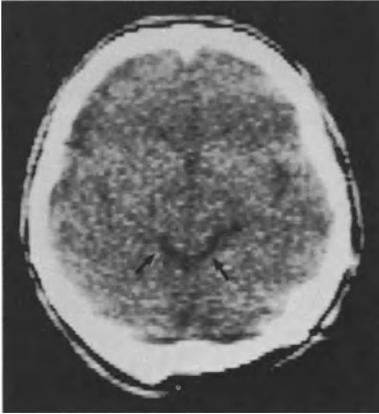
CT image 3 weeks after surgery shows normal cisterns (*black arrows*) and upper brain stem
